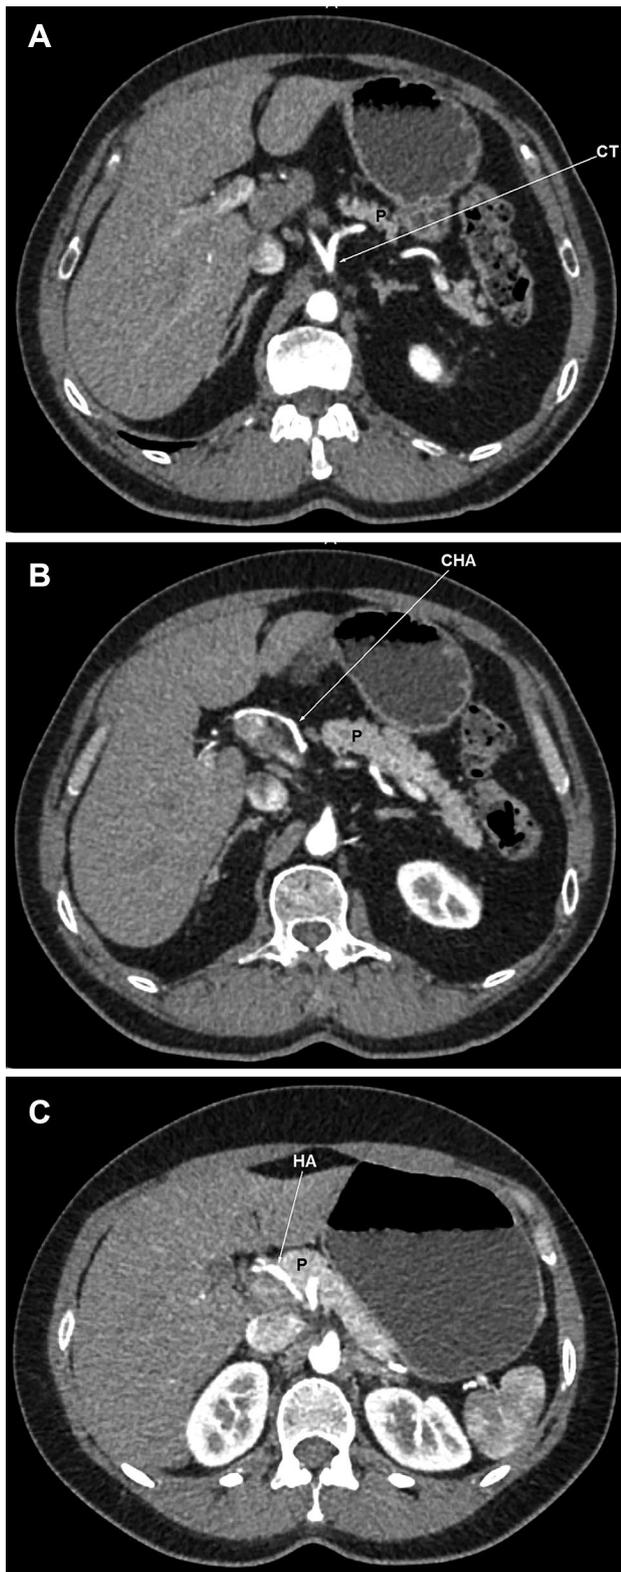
a, c Visible fat planes between the pancreatic body (P) and coeliac trunk (CT) (a), and more caudally, towards the common hepatic artery (CHA) in a 61-year-old man with a body mass of 85 kg and BMI of 28.7 kg/m² (b). Invisible fat plane towards the hepatic artery (HA) in a 38-year-old lean woman with a body mass of 60 kg and BMI of 20.8 kg/m² (c)
